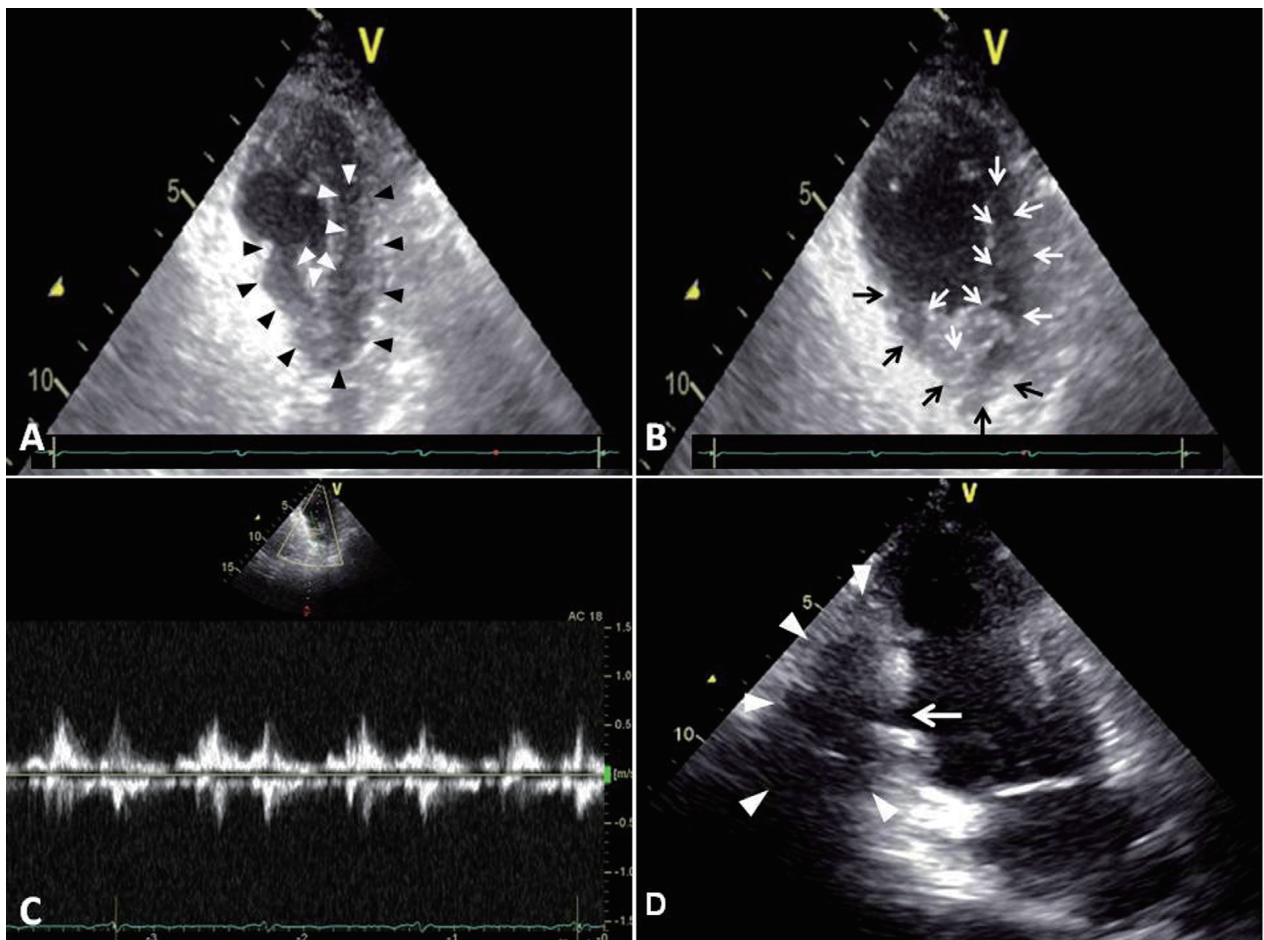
The most recent follow-up transthoracic echocardiograms. The parasternal short-axis views at the end-systolic phase (A) and end-diastolic phase (B) show an tubular-like echo-free space posterior to the inferoposterior wall (pseudoaneurysm, white arrows) without contractility (black and white arrowheads in A) and with organized thrombi (black arrows in B). C. Doppler flow demonstrates blood flow entering the pseudoaneurysm. D. Apical 2-chamber view shows a saccular contour (white arrowheads) of the pseudoaneurysm with a narrow neck (arrow) connecting it to the left ventricle. LA = left atrium; LV = left ventricle.
